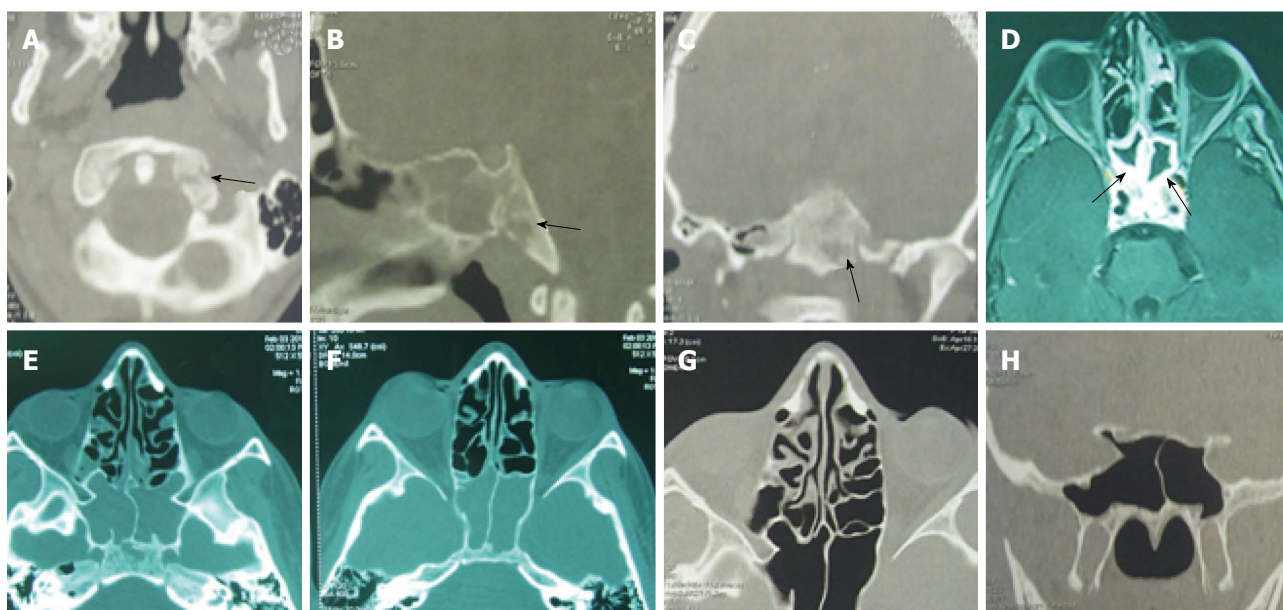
Sphenoiditis with bony lysis and a notable regression of the inflammatory lesions in a 9-year-old child. Sphenoiditis in a 9-year-old child with bony lysis in computed tomography-scan (A, B and C) and magnetic resonance imaging (D). The regression of the inflammatory lesions after sphenoidotomy and antibiotherapy was partial after 3 wk (E and F) and complete after 5 wk (G and H).
